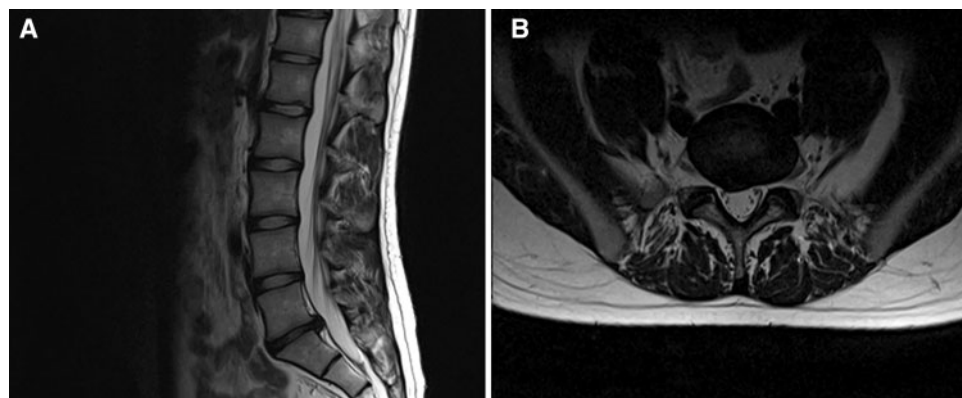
(A) Sagittal T2W magnetic resonance imaging (MRI) of lumbar spine depicting herniation of generatively changed L5-S1 intervertebral disc with the reduction of ventral subarachnoid space. (B) Axial T2W MRI of right-sided dorsolateral soft disc herniation that reduces ventral subarachnoid space.
